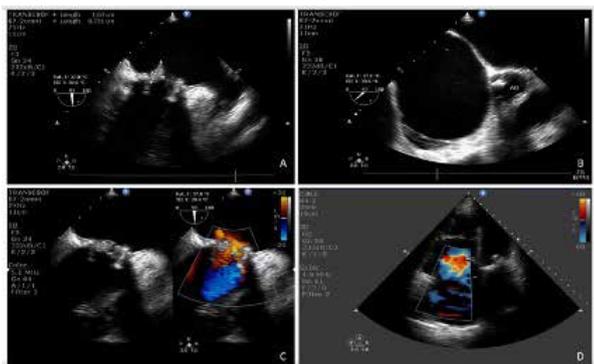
Perioperative transesophageal echocardiogram A) Thickening of the mitral valve leaflets. B) Right ventricular enlargement. C) Mitral stenosis demonstrating regurgitation by Collor. D) Tricuspid insufficiency.
